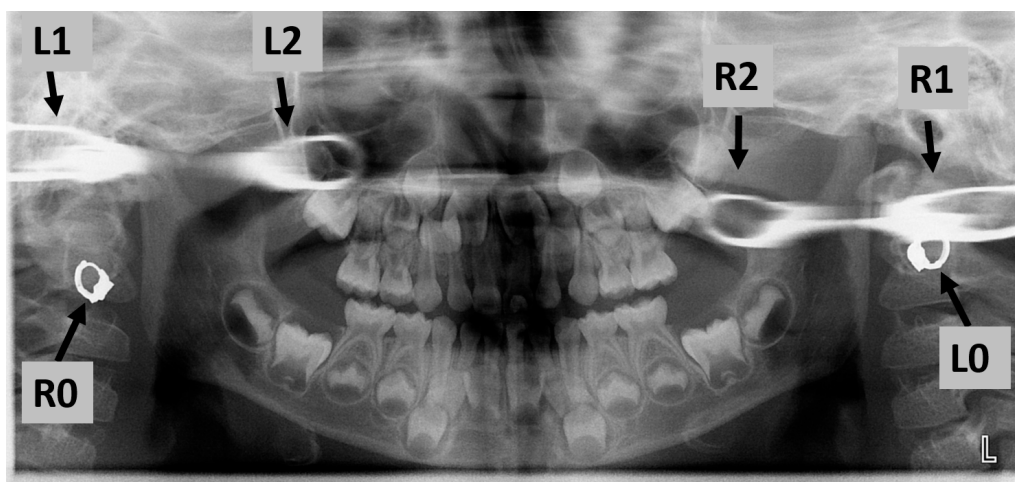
Triple images formed by right and left earrings on a panoramic radiograph. Note that each earring (R0 and L0) makes two ghost-like images: an atypical ghost-like real (pseudo-ghost) image (R1 and L1) and a typical ghost image (R2 and L2).
